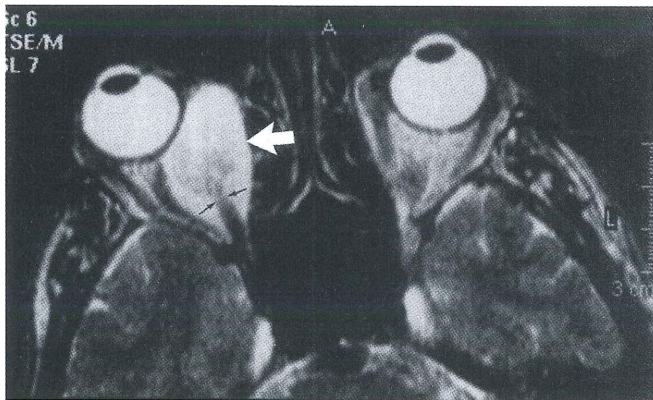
Orbital MRI. T2-weighted axial image demonstrating elongated hyperintense mass (white arrow) in the medial aspect of the right orbit. Note the tubular hypointense structure within the mass (thin black arrows) representing the patent lumen of the varix.
